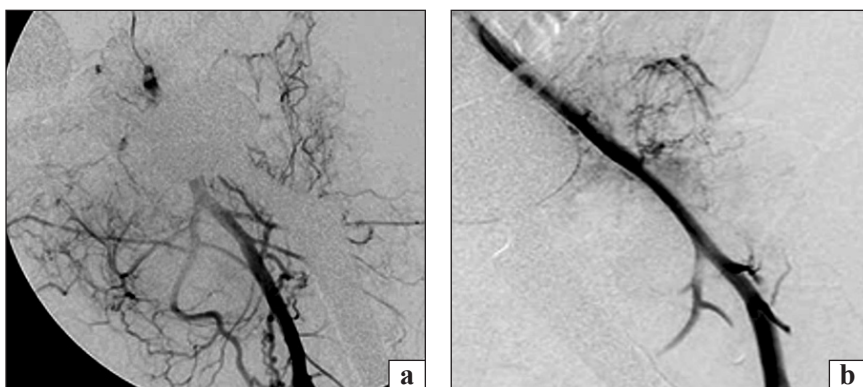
DSA examination executed two months after the previous CT. Partial reperfusion of both the medial and lateral circumflex arterial branches (a). Angiographic control after further embolization: although good devascularization was achieved, a few arterial micro-vessels could not be occluded for lack of stable catheterization (b)
